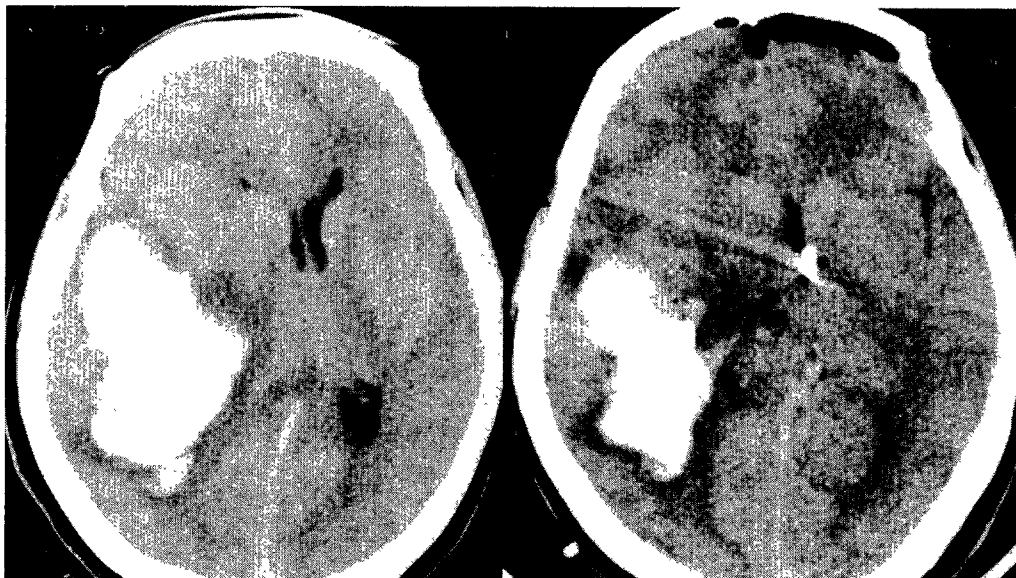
Case 8. Computerized tomography(CT) scans obtained in an 80-year-old woman with a large right putaminal intracerebral hemorrhage. Upper: Admission CT scan showing compression of the right lateral ventricle and midline shift to the left with some intraventricular hemorrhage(Day 0). Lower: Cranial CT scan obtained approximately 12 hours after the patient underwent the SER procedure. Note the significant decrease of midline shift and reduction of hematoma size(Day 1) and the artifact caused by the trajectory of the inserted ventricular and parenchymal catheters.
